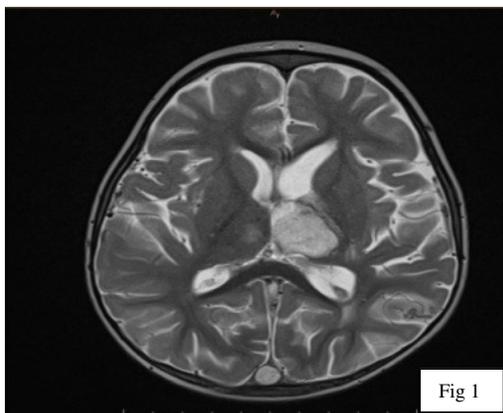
Brain MRI showed bilateral thalamic infarction and left hemorrhagic transformation with intraventricular hemorrhage and uni-ventricular obstructive left hydrocephalus with transependymal resorption edema by obstruction foramina of Monro with mass effect
